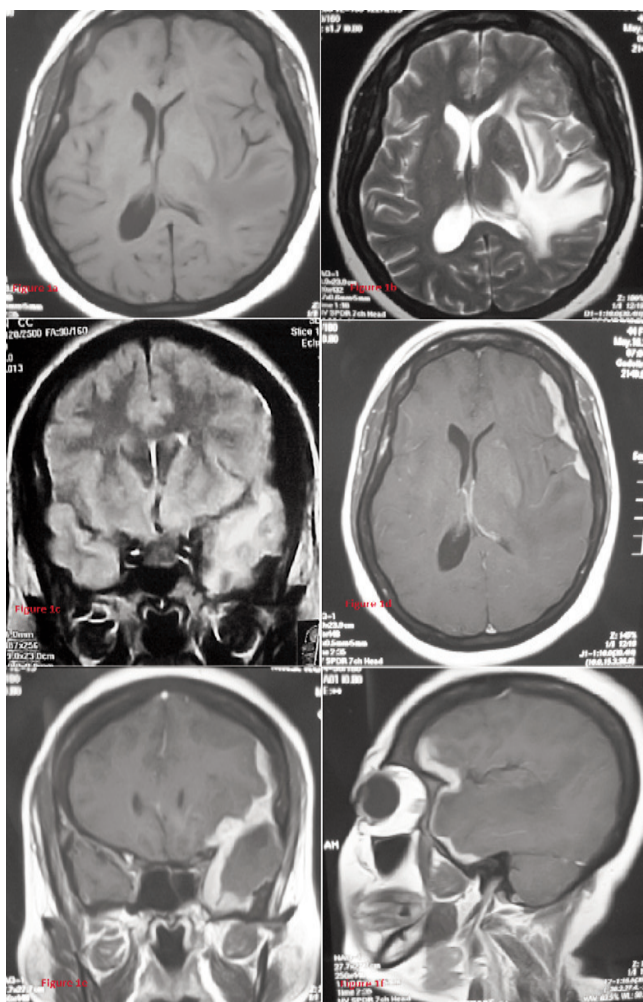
An extra axial, dural based, extensive ring of soft tissue nodular mass in the left parasellar region, surrounding a portion of the left temporal lobe. The mass extended from high frontal convexity to the left clinoid process. Vasogenic edema involving the underlying left temporal lobe and right subfalcine herniation is seen. (a)The lesion was isointense to the parenchyma on T1WI.(b & c) Hypointensity was seen on T2W and FLAIR images.(d,e,f) Post contrast axial, coronal and sagittal images demonstrate diffuse and homogenous enhancement of the lesion.
